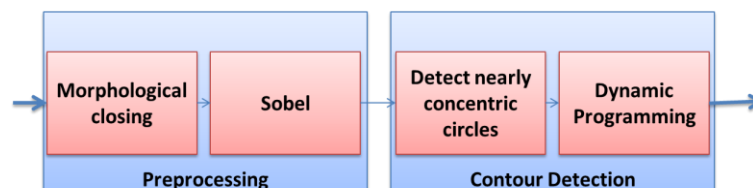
Block scheme for segmentation in t-MRI using the strategy proposed in [76].
